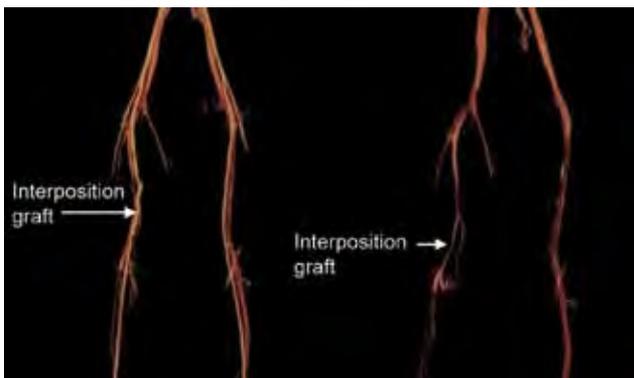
Computed tomography angiography in the postoperative period showing patent arterial (left) and venous (right) grafts
